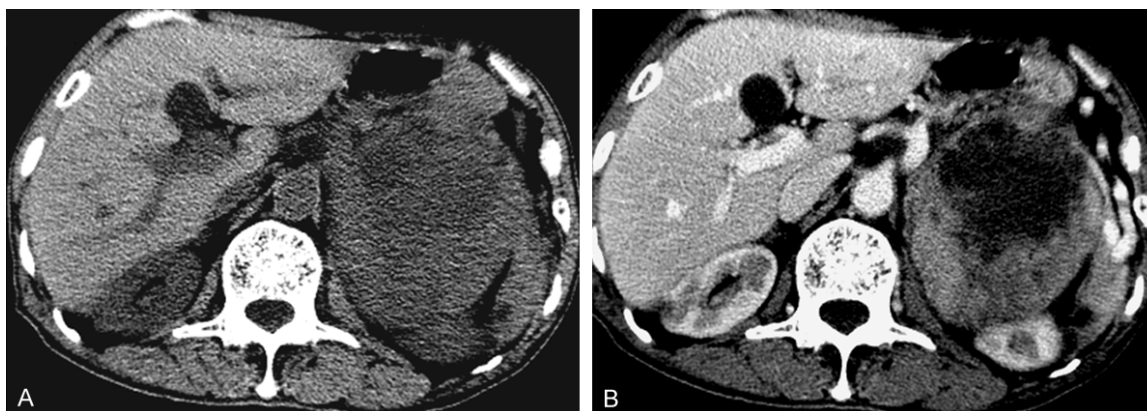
A 60-year-old male with cortical carcinoma of the left adrenal gland. A. The mass shows heterogeneous attenuation with patchy low attenuation area on non-enhanced CT. B. The mass presents moderately heterogeneous enhancement after contrast administration.
